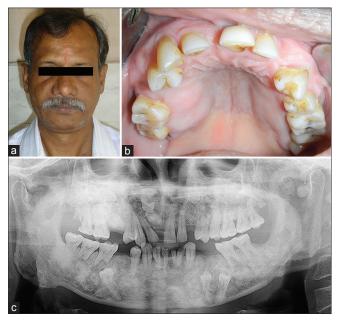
(a) Extraoral photograph shows fullness of nasolabial folds on both sides with small bony swellings seen on the right temple region. (b) Bony swellings seen on the right and left sides of the palate. On the right side, buccal vestibule is obliterated in 14 and 15 region and palatal swelling is extending from the mesial aspect of 16 to the distal aspect of tooth 17 anteroposteriorly. On the left side, the palatal swelling is extending from mesial aspect of tooth 25 to the mesial aspect of 28 anteroposteriorly. Teeth missing is 11, 15, and 23. (c) Orthopantomograph shows impacted teeth w.r.t. 11, 15, 23, 34, 35, and 45. Resorption of the roots w.r.t. 46 and 47 is noted. Dense radio-opacities are seen on the right and left maxilla in premolar-molar region. Maxilla and mandible show diffuse radiopaque areas suggestive of dense bone islands or enostoses. Surgical defect seen on the left lower border of mandible and a well-defined round radio-opacity is seen on the left sigmoid notch
